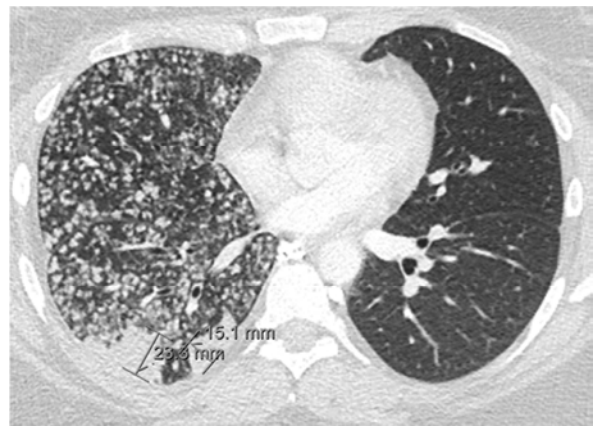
CT chest with numerous unilateral small pulmonary nodules throughout the right lung.
